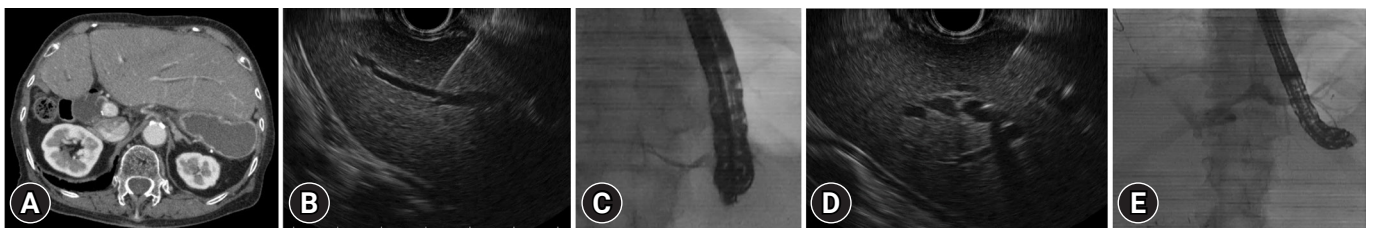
Endoscopic ultrasound and fluoroscopic images of a patient with unsuccessful guidewire manipulation in the B2 puncture group. (A) Abdominal computed tomography reveals swelling of the left lobe. (B) The first puncture angle between the needle and the intrahepatic biliary tract was acute. (C) The guidewire was only inserted into the peripheral bile duct. The scope was not directed toward the hilar side. (D) We re-punctured another bile duct, and the puncture angle between the needle and the intrahepatic biliary tract was obtuse. (E) The guidewire was easily inserted into the hilar bile duct. The scope was toward the peripheral side.
